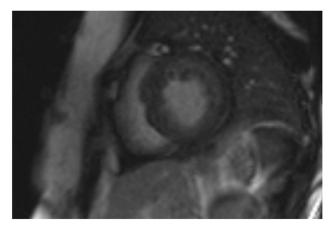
Cardiac MRI showing concentric left ventricular hypertrophy.
